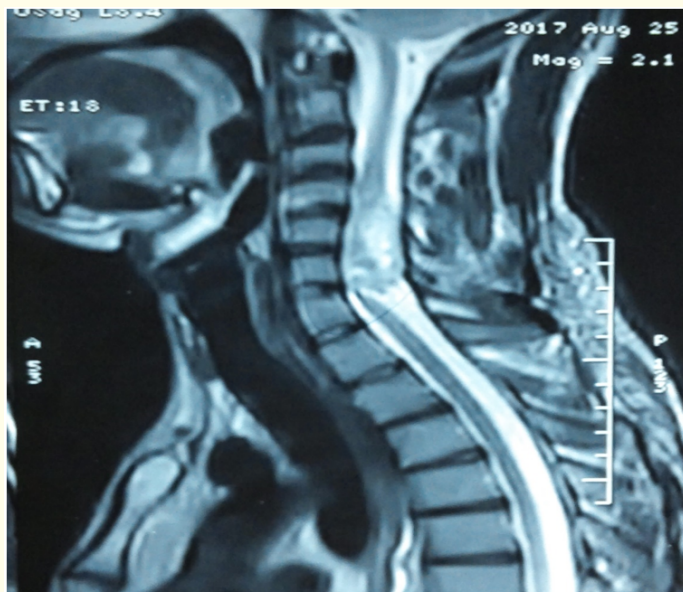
MRI cervical spine with T1W and T2W images showing neurofibroma at C4, C5, C6 levels.
